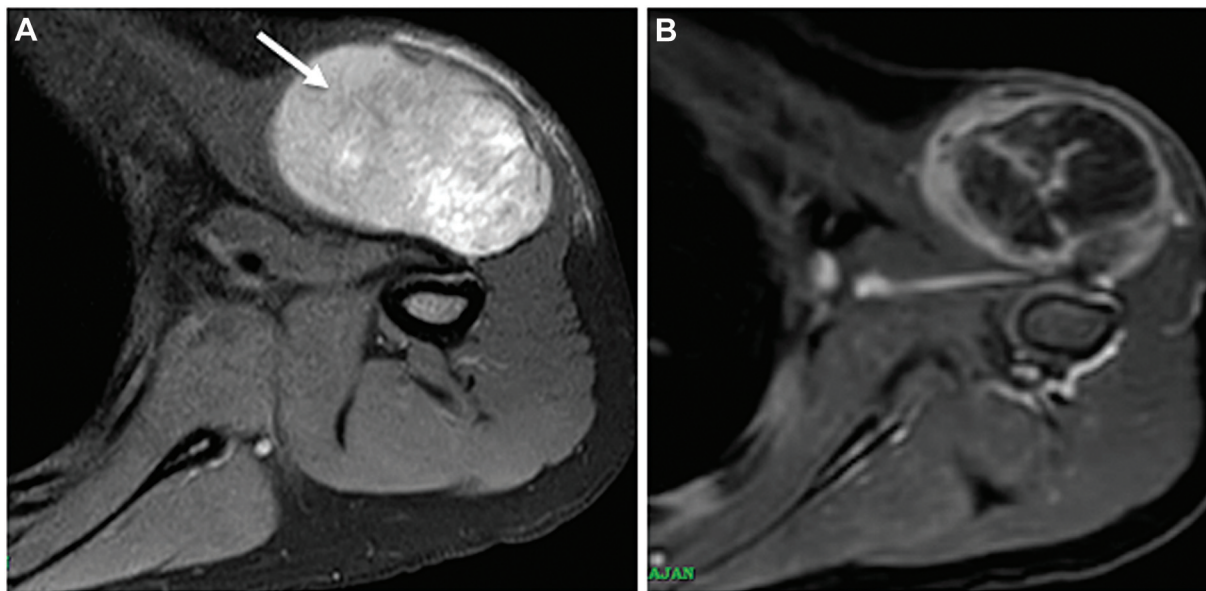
T2-weighted MRI showing a hyperintense soft tissue mass in the left shoulder with heterogeneous enhancement, involving the deltoid muscle (arrow). No erosion of underlying bone seen.
